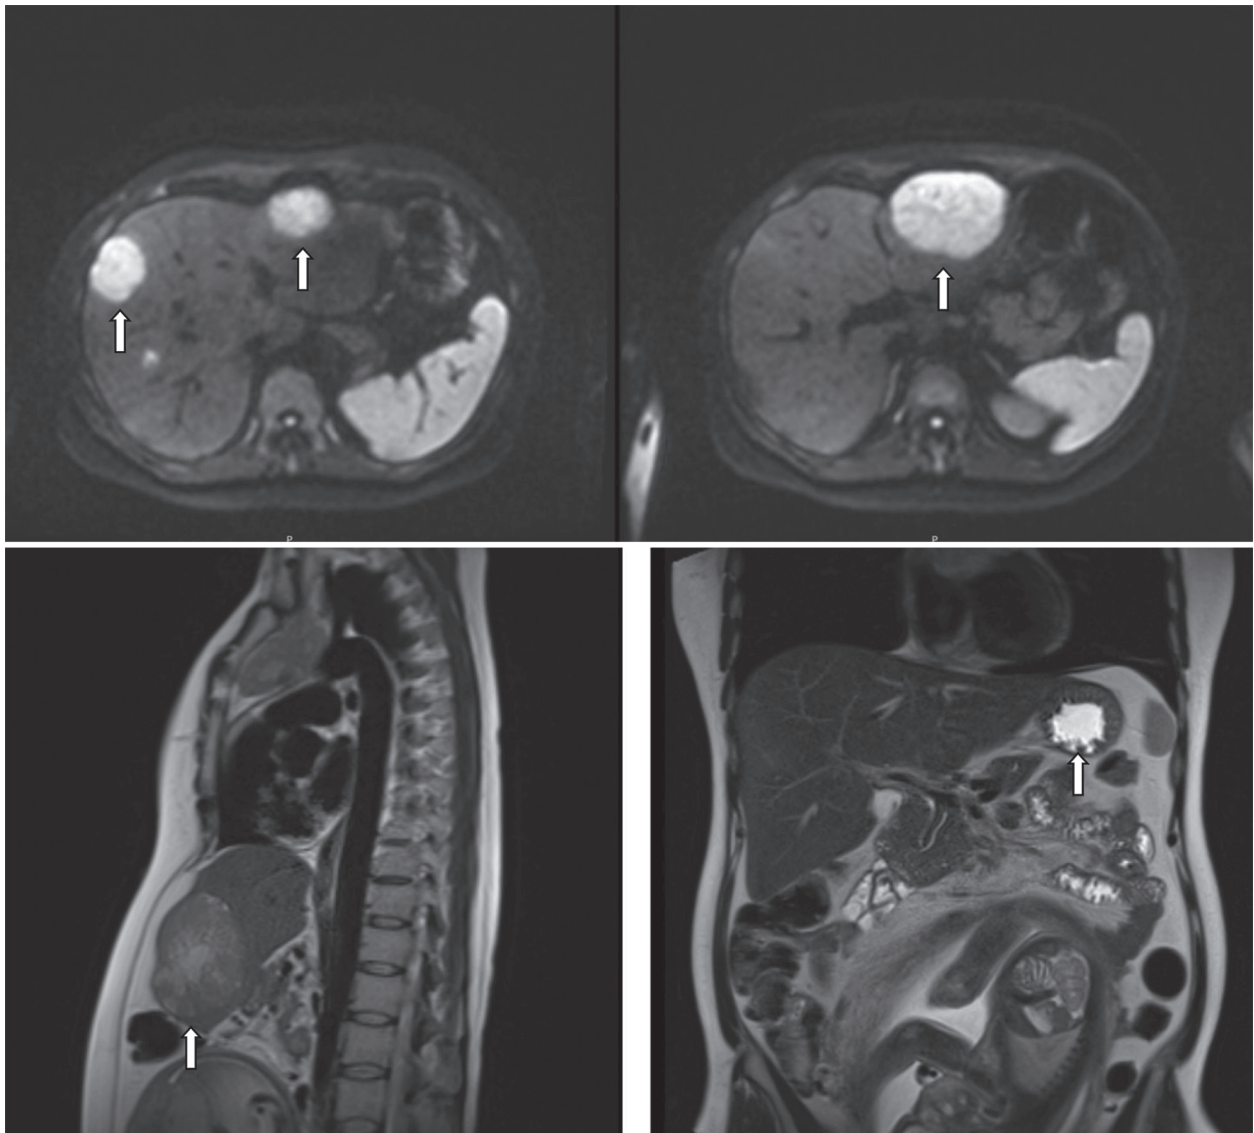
Preoperative MRI of abdomen – white arrow indicates the tumor masses
